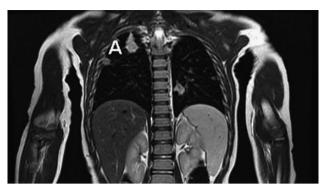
Magnetic resonance imaging sections in phase T2 with enhancing lesions found in bilateral apices and lung parenchyma (demonstrated by A).
